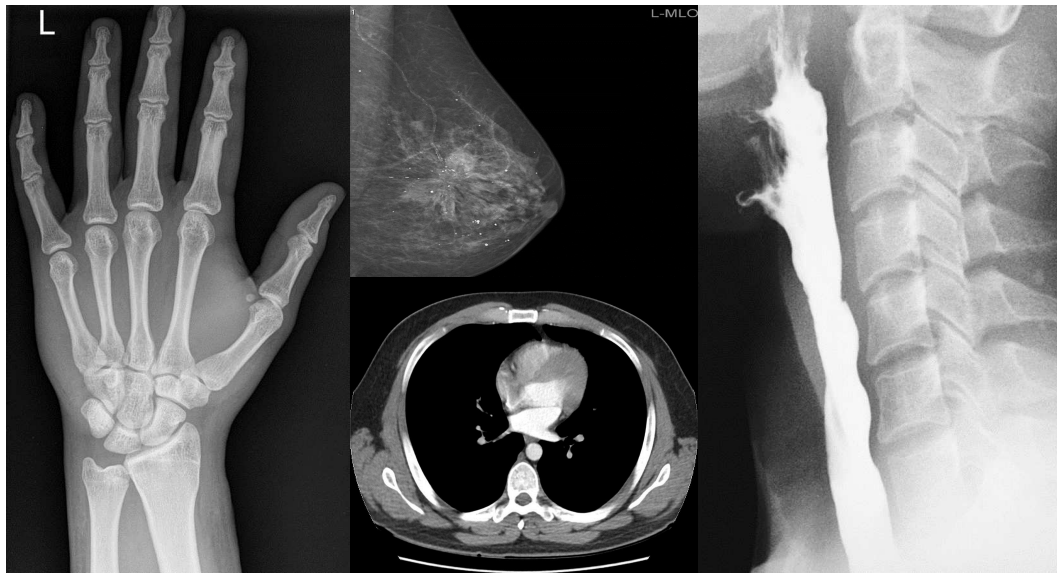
Radiographic image of the hand (left). Mammography image of the breast (top middle). CT image of the thoracic area (bottom middle). Barium swallow study under fluoroscopic image guidance (right). Case courtesy of Mr Andrew Murphy, Radiopaedia.org, rID: 48226. Case courtesy of A.Prof Frank Gaillard, Radiopaedia.org, rID: 12608. Case courtesy of Dr Andrew Dixon, Radiopaedia.org, rID: 36676. Case courtesy of Dr Ian Bickle, Radiopaedia.org, rID: 53859.
